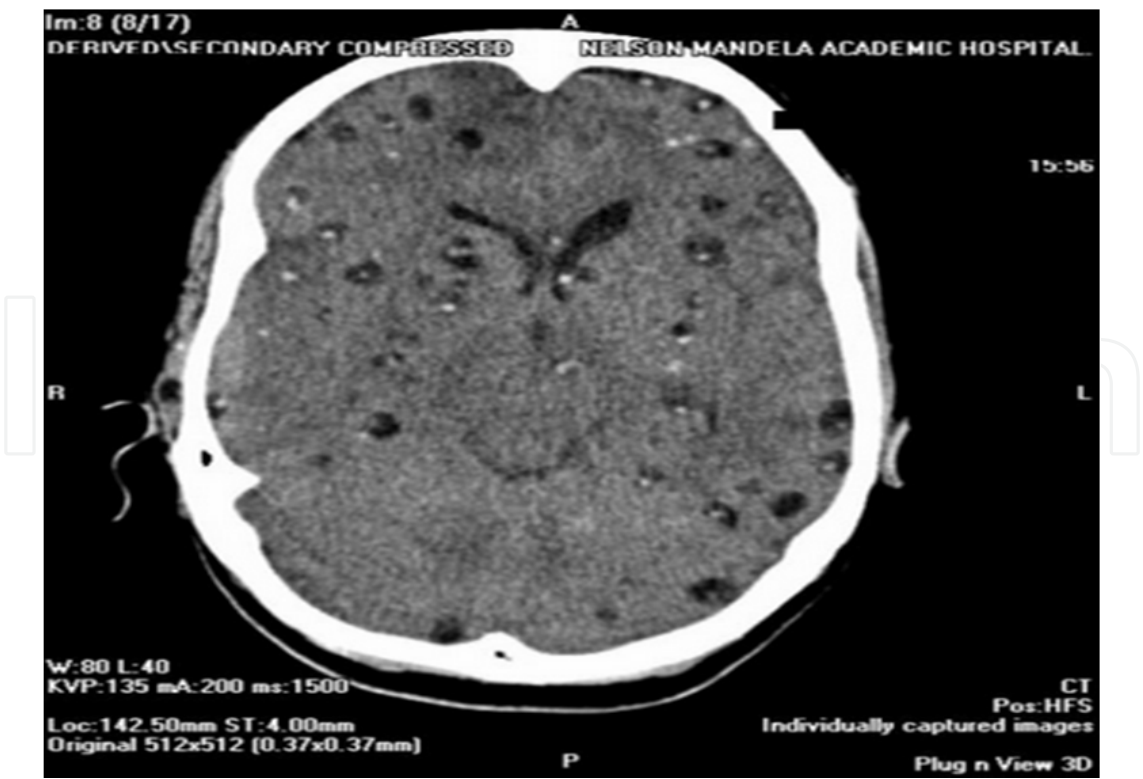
CT scan of the brain showing multiples intraparenchymal cysticerci in vesicular, colloid and calcified stages.
